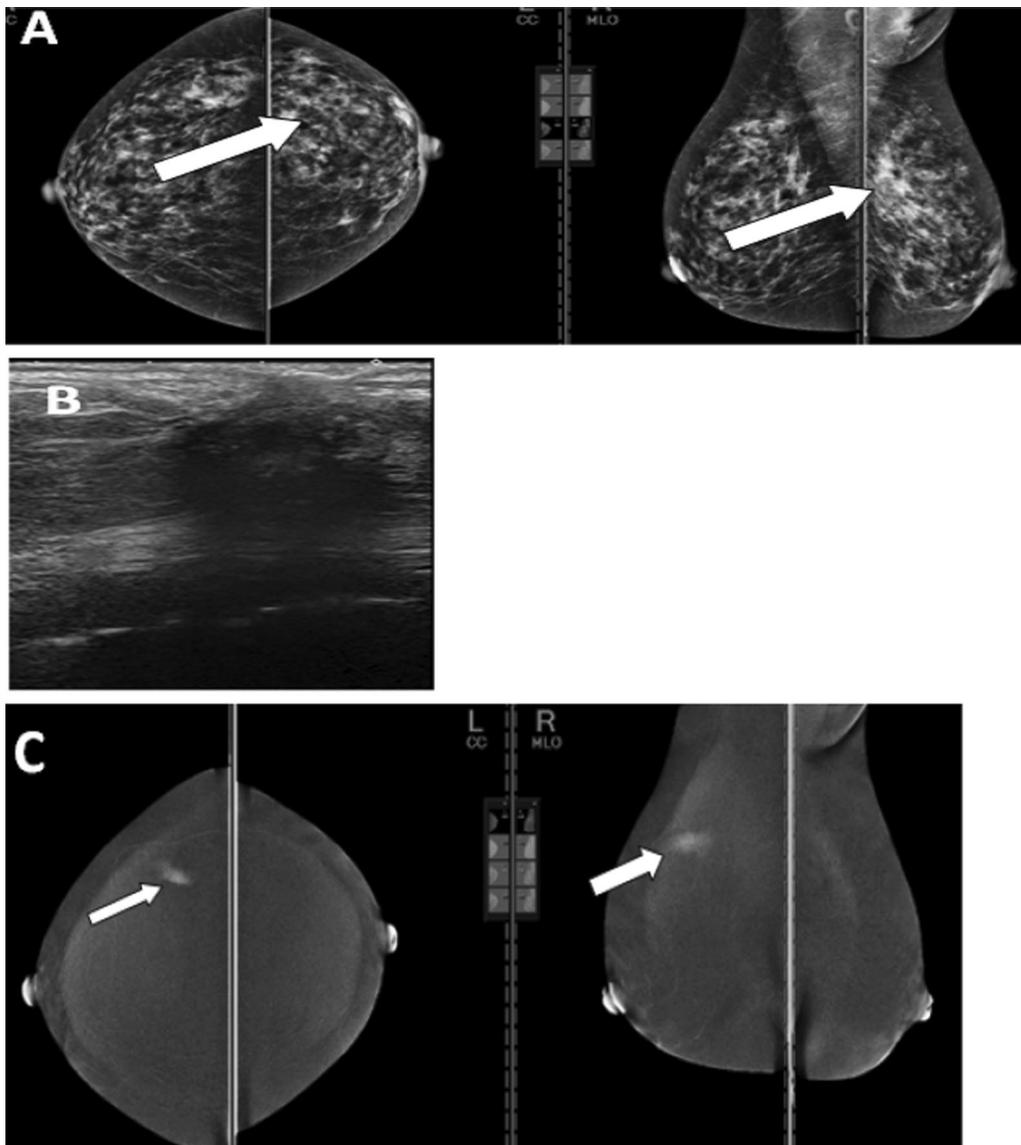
An 80-year-old asymptomatic female patient underwent left CBS for mucinous carcinoma, presenting for her annual follow-up. A Mammography (CC and MLO views) revealed: Breast density ACR 'C' with heterogeneous fibroglandular densities and nodulations. Asymmetry is seen at left UOQ with mild skin thickening (white arrow). B Complementary ultrasound revealed: operative bed hypoechoic scarring is seen at left UOQ with no vascularity on color Doppler. C Contrast-enhanced spectral mammography revealed: enhancing focus at right UOQ (white arrow), No operative bed-enhancing masses. Final pathology: right breast mucinous carcinoma (contralateral newly developed lesion). Final comment: In this case, sonomammography could not detect the contralateral newly developed lesion, while CESM revealed a contralateral enhancing lesion and excluded operative bed lesions
